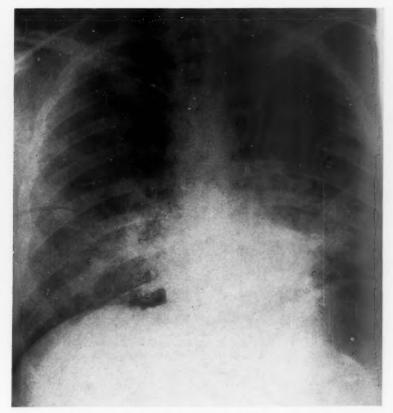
Chest x-ray, February 12, 1957, showing diffuse, soft, coarsely nodular infiltrates in the lower lung fields.
